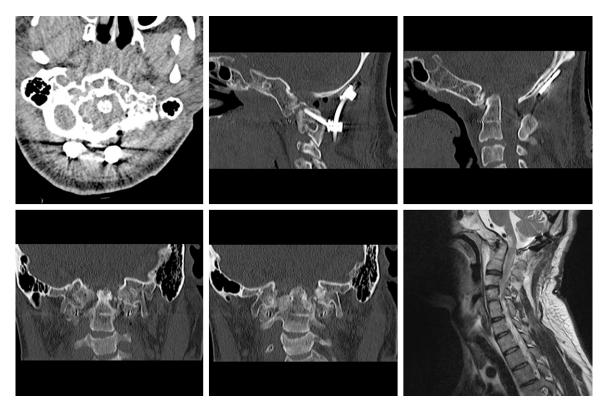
Images provided by CT and MRI after surgery.
